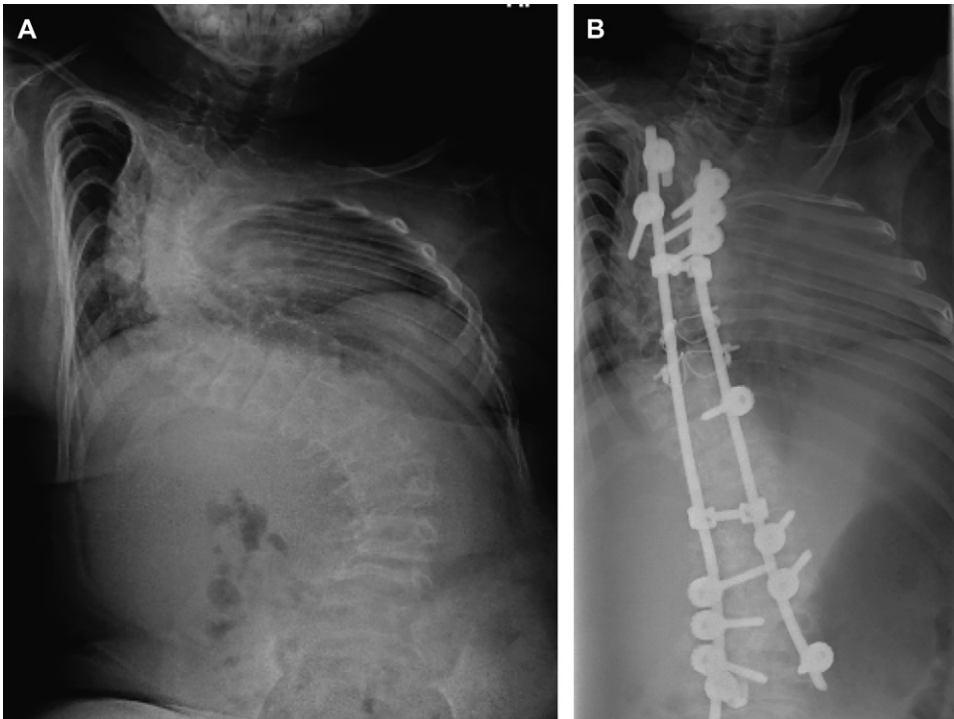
OI results from microfractures near the vertebral growth plates yielding vertebral compression and spinal ligament laxity. (A) It ultimately results in severe scoliotic deformities of the spinal axis, as is depicted in this preoperative coronal plain film in a patient who has type III OI. (B) Postoperative anteroposterior radiograph after thoracolumbar correction and fusion.
